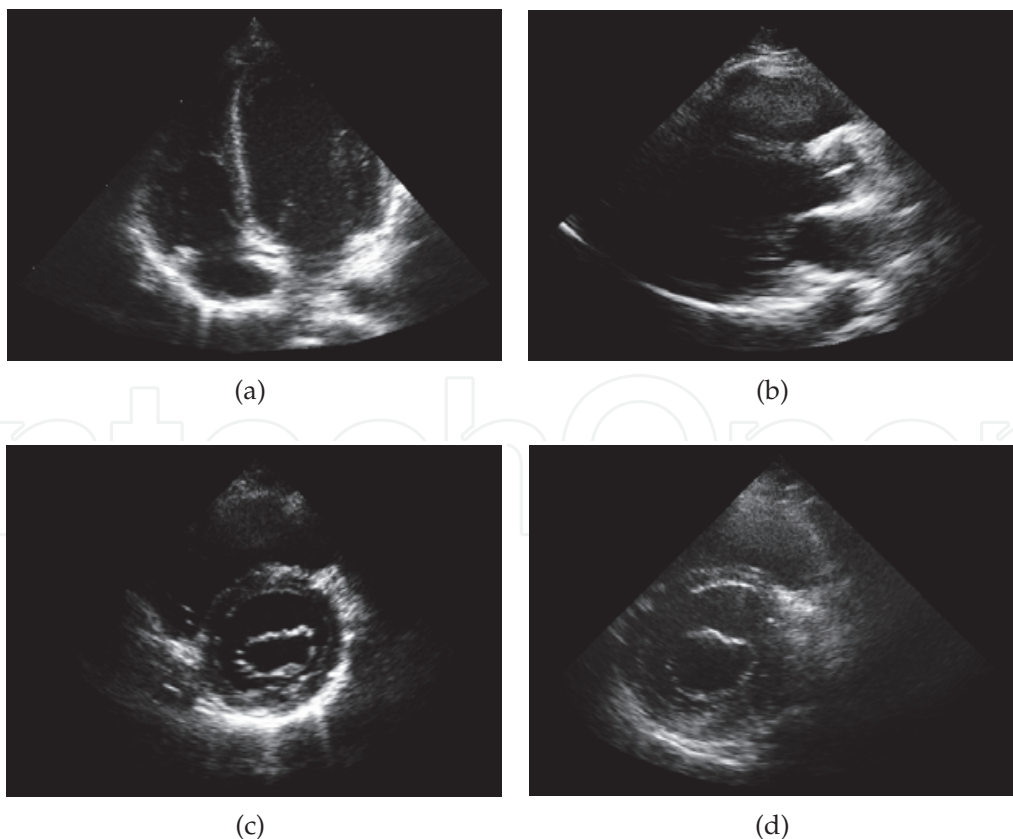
Clinical ultrasound images, used in speckle filter evaluation.
